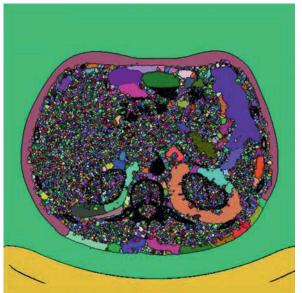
Applying watershed segmentation to the CT image from Figure 4.2a. a Shows catchment basins. b A smoothing filter (averaging the 3 × 3 neighbourhood of each pixel) is applied before the watershed. Images produced using the watershed plug-in for ImageJ (SAGE 2005)
